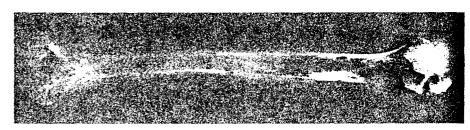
Above: Post-mortem radiographs of two portions of the patient's calvarium, showing radiographic changes. Below: Post-mortem radiographs of the patient's humerus, showing similar radiographic changes, i.e. osteolysis, etc., to those seen in the calvarium.
